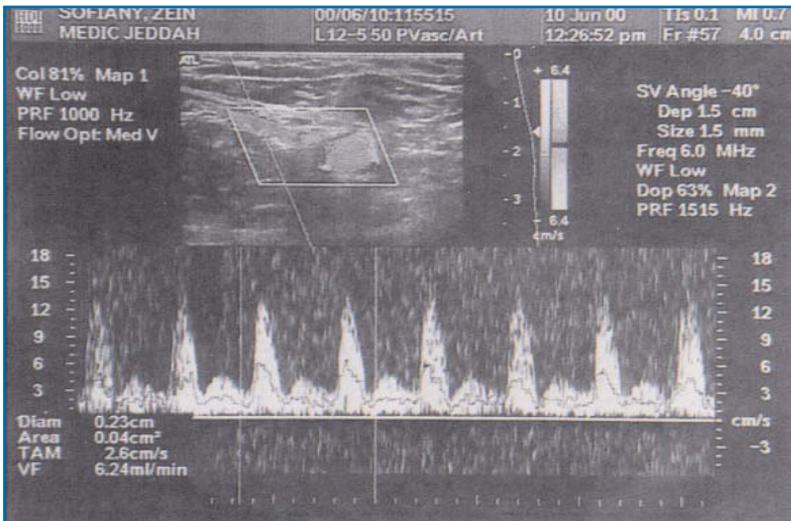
Doppler ultrasound with excellent uterine artery filling
